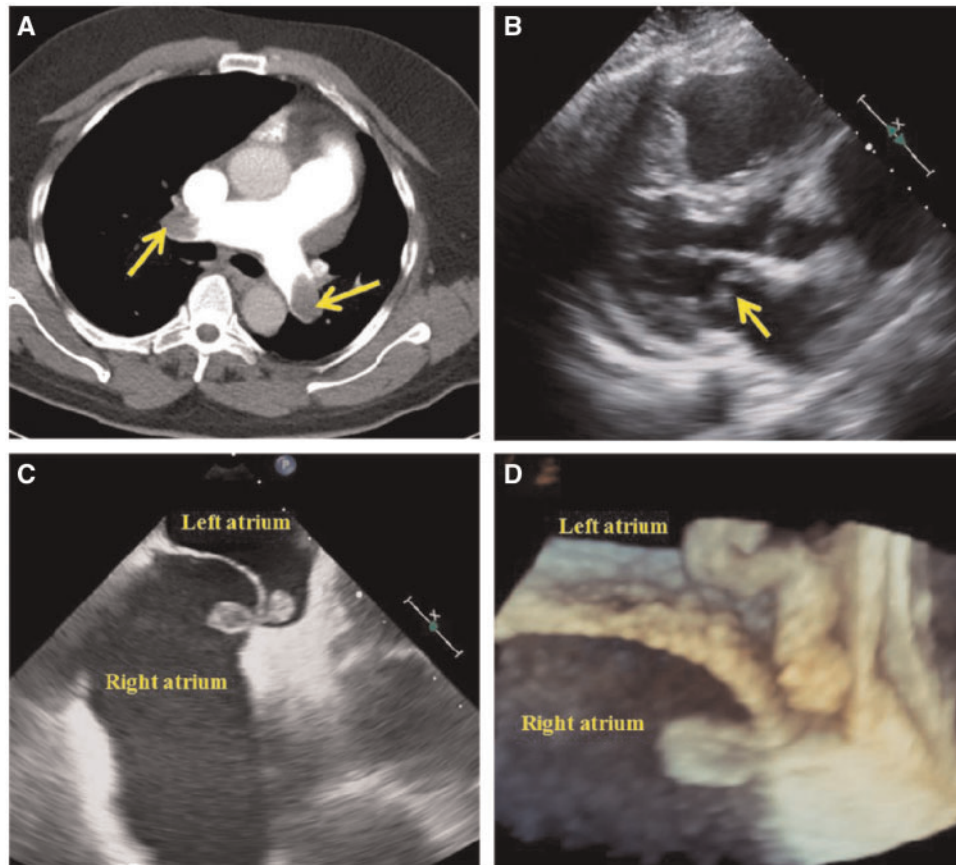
Multi-modality imaging of 'thrombus in transit' in a patient with a patent foramen ovale. (A) Bilateral pulmonary embolic on computed tomography. (B) Thrombus on the mitral valve on transthoracic echocardiography. (C, D) Large thrombus trapped in the patent foramen ovale tunnel on transesophageal echocardiography. Reproduced with permission from Biglane *et al.*¹⁷
